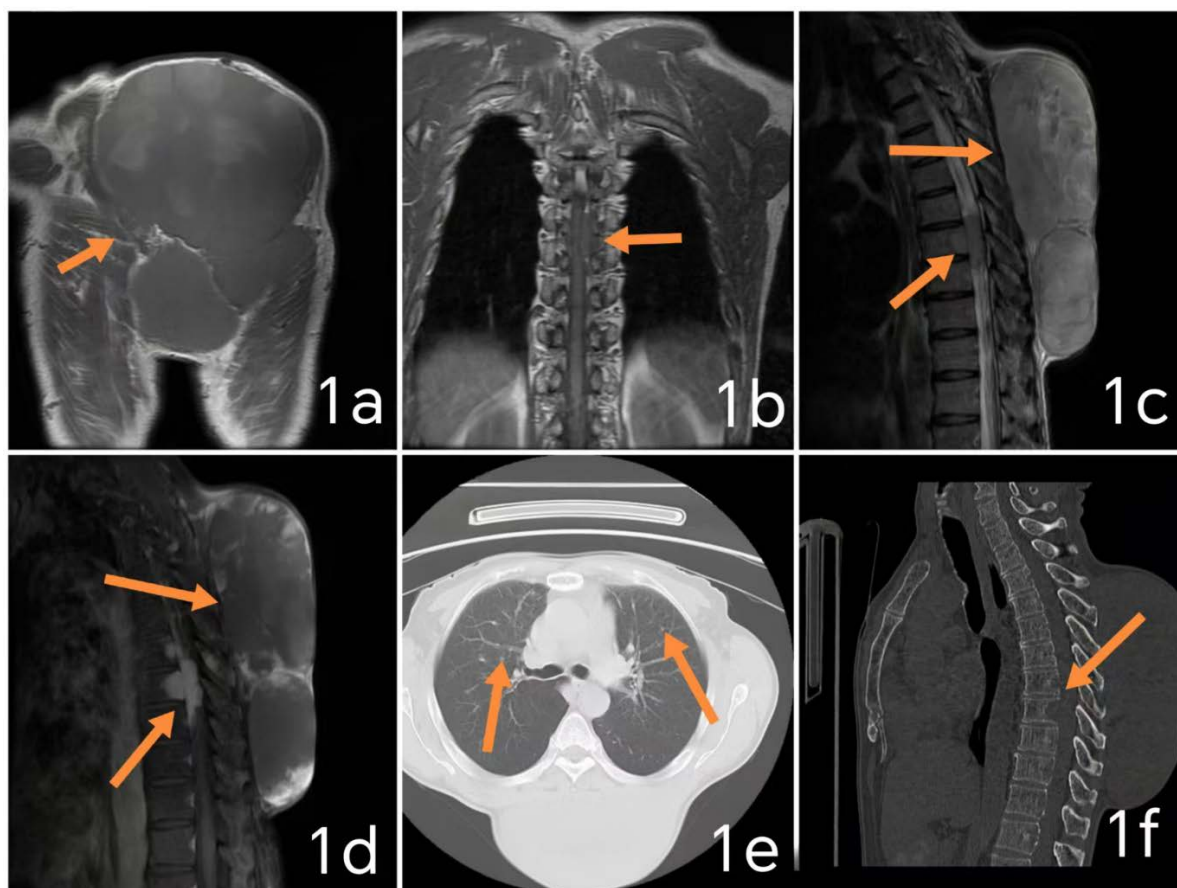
(1) In Figure 1a (arrowhead), on T1WI, the dorsal skin mass shows mostly isosignal, with multiple slightly hyperintense signals within the lesion, and linear hypointense septations can be seen locally. In Figure 1c (long arrowhead), on T2WI, the lesion shows mostly hyperintense signal, with isointense and slightly hyperintense signals within the lesion, and linear hypointense septations can be seen locally. Fat tail sign, skin tail sign, and fascia tail sign can be observed. In Figure 1d (long arrowhead), on enhanced scanning, multiple patchy areas of significant enhancement of varying sizes can be seen at the edge of the dorsal mass and within the lesion. (2) At the level of the T7 - T8 vertebral bodies, there are strip-shaped and nodular masses in the epidural space of the spinal canal. In Figure 1b (arrowhead), on T1WI, it shows isosignal, and in Figure 1c (short arrow), on T2WI, it shows slightly hyperintense signal. The mass invades the posterior edges of the adjacent T7 and T8 vertebral bodies. In Figure 1d (short arrow), on enhanced scanning, the mass shows significant enhancement, compressing the dural sac and spinal cord. Diagnosis: Subcutaneous soft-tissue mass on the back, consistent with the manifestations of dermatofibrosarcoma protuberans; mass in the epidural space of the spinal canal at the T7 - T8 level, involving the posterior edges of the T7 and T8 vertebral bodies, considered as metastatic tumor. (2) CT diagnosis: Subcutaneous soft-tissue mass on the back, consistent with the manifestations of postoperative recurrence of dermatofibrosarcoma protuberans; nodules in both lungs (Figure 1e) (arrowhead), and bone destruction of the T7 and T8 vertebral bodies (Figure 1f) (arrowhead), considered as metastases.
